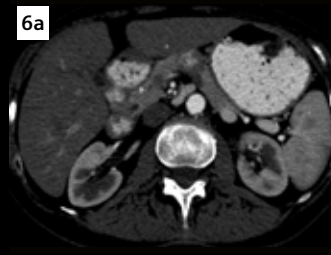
An axial VMI, acquired in the arterial phase and displayed at 50 keV, shows a small hypervascular nodular lesion in the pancreatic body (Fig. 6c, arrow). The lesion is neither shown in a previous EID-CT image (Fig. 6a) nor evident in a standard image reconstruction (Fig. 6b).
